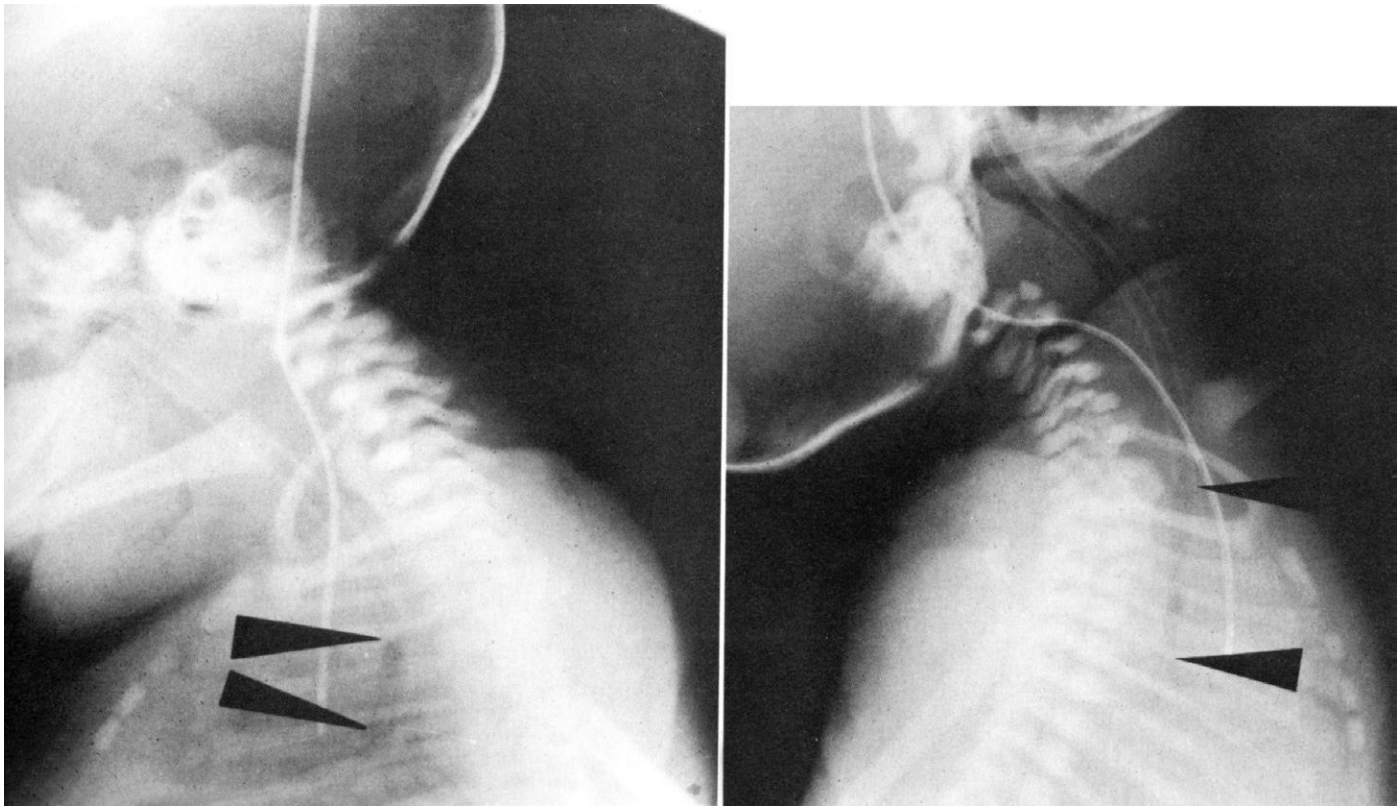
Reprint of x-ray photos showing endotracheal tube position changes with head position changes. (From Todres ID, deBros F, Framers SS, et al: *J Pediatr* 89:126-127, 1979.)
